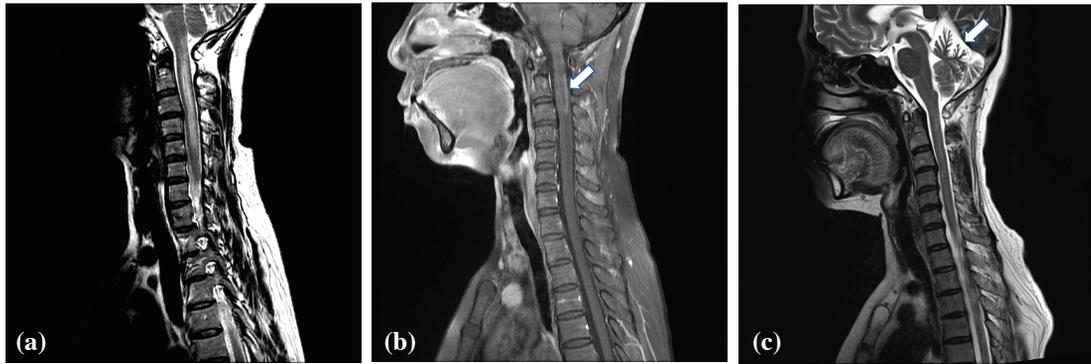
(a) Sagittal cervical spine T2-weighted MRI showing a high signal intensity lesion at C1 and C6 level and lower medullar. (b) Gadolinium enhanced T1-weighted MRI reveals enhanced lesion in C2-3 level (arrow). (c) Follow-up MRI shows cerebellar atrophy (arrow) and improved high signal intensity lesion in previous MRI.
